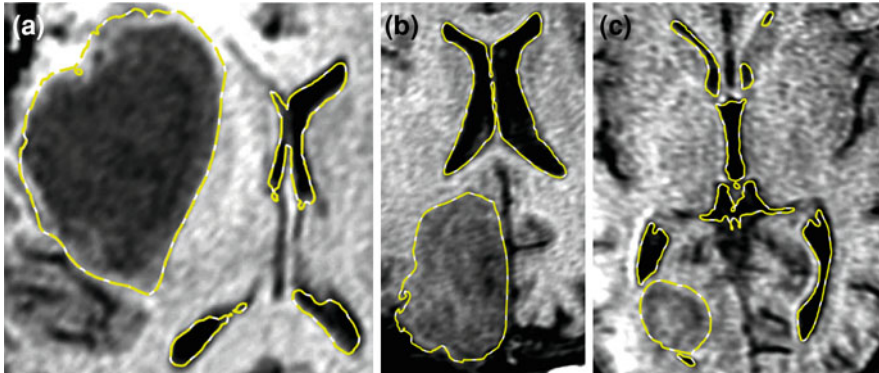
Transverse contours of the tumour and ventricles in Case 3(a), 4(b), and 5(c), computed using the complete model (Model A, *White*) and homogenous one (Model C, *Yellow dash line*) are imposed on the intra-operative MR images. We selected the sections in which both the tumour and ventricles are clearly visible. The contour overlaps and there is no observable difference for the scale shown
